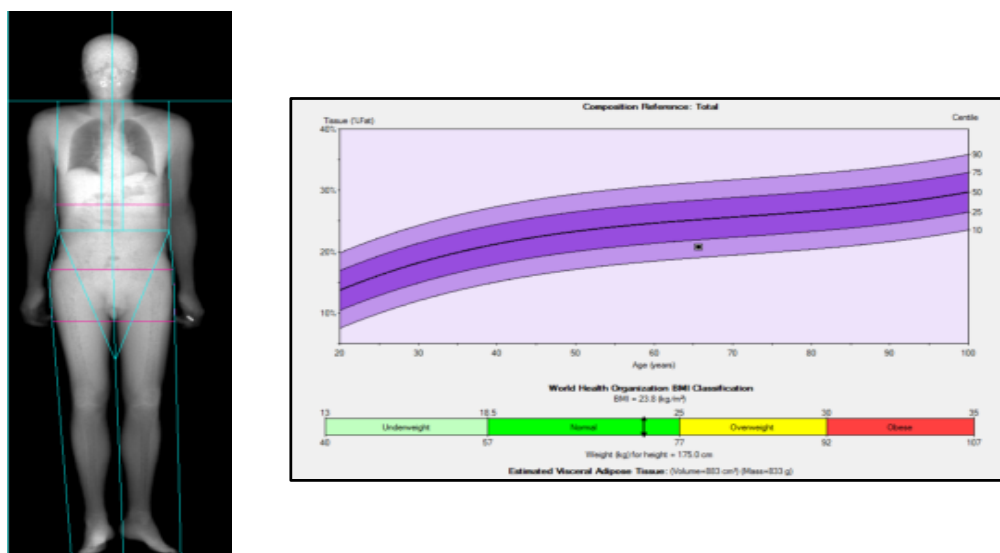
Dual Energy X-ray Absorptiometry This figure depicts the fat mass and distribution seen on DEXA, BMI and the fat mass as a percentage of total mass. Additionally, it provides detail of where the mosaic individual fat mass percentage lies on a population distribution.
